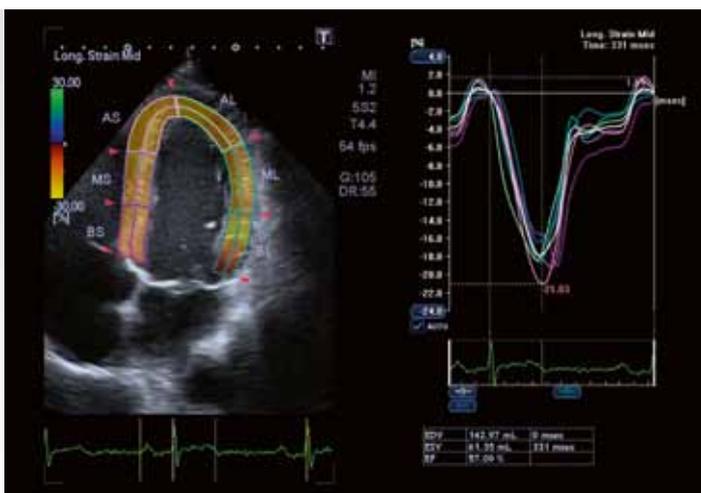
The automatic strain analysis in Case 1 – a patient with no significant coronary artery stenosis. The image on the left is a colour coded longitudinal strain image acquired from an apical four-chamber view. Strain curves for the six myocardial segments are displayed on the right.
